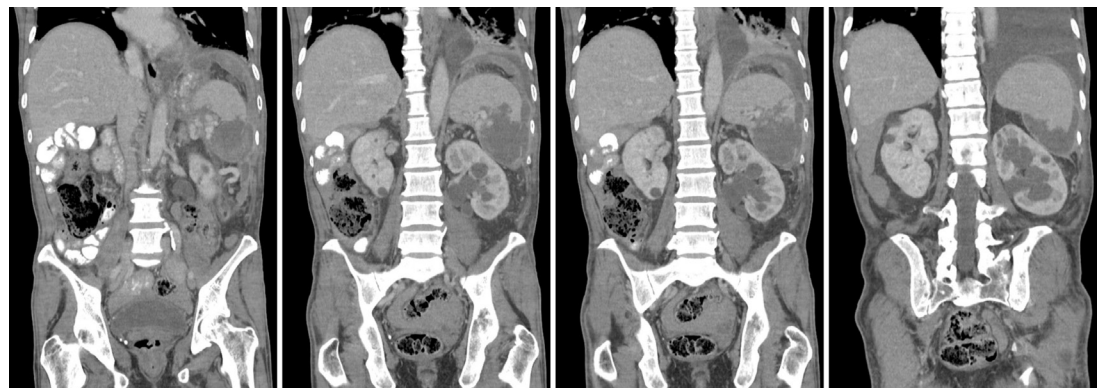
CT with intravenous contrast demonstrating non-enhancing lower pole of the spleen related to a subacute traumatic infarct with liquefaction and rupture through the lateral capsule. There is hyperdense layering and fluid tracking along the diaphragm, paracolic gutter and pelvis suspicious for subacute haemorrhage with superimposed infection. Moderate left hydroureteronephrosis without obstructing lesion consistent with chronic ureteropelvic junction obstruction.
